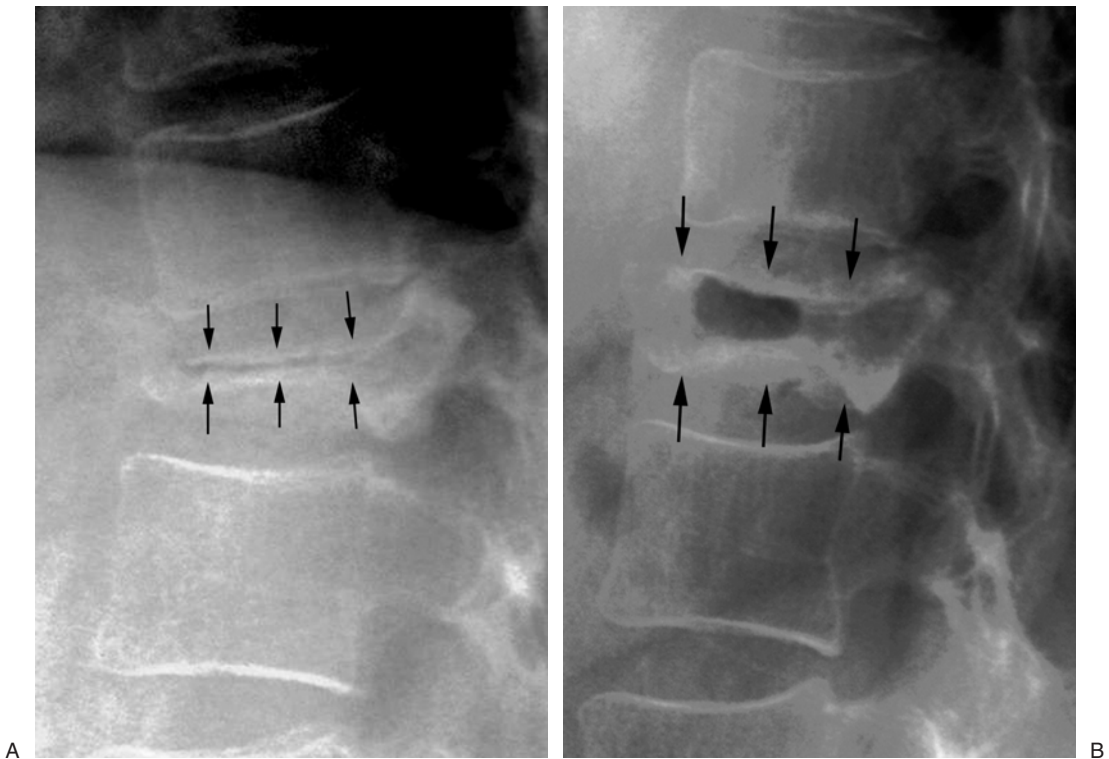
(A) Lateral radiograph shows a markedly collapsed vertebral body (black arrows). The patient is standing. (B) The mobility of the vertebrae (black arrows) is demonstrated with the patient lying prone. This mobility is consistent with vertebral nonunion. Percutaneous vertebroplasty will recapture the height gained during prone positioning.
